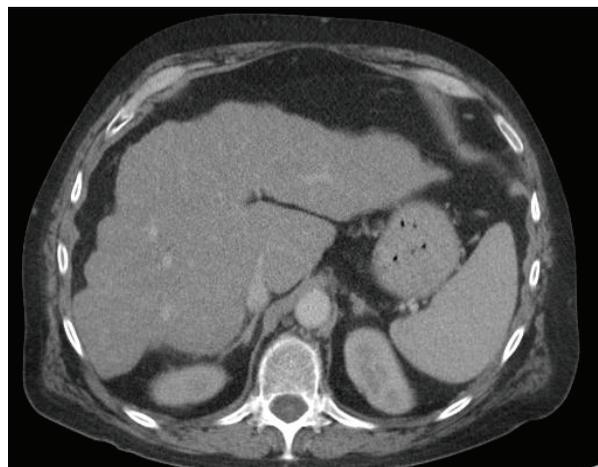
CT abdomen: macronodular liver cirrhosis
